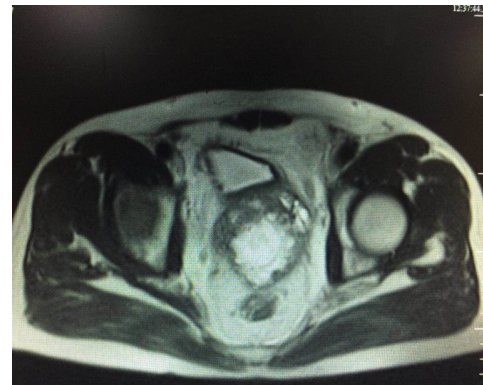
Prostate MRI showing prostate enlarged measuring about 6.6X6.8X9.6cm, slightly longer T1 signal shadow, see flaky liquefaction zone, enhanced scan solid region unevenly enhanced, partial capsule is not complete, consider the probability of prostate Ca, the rectum not invaded, no evidence of pelvic lymphadenopathy was found.
